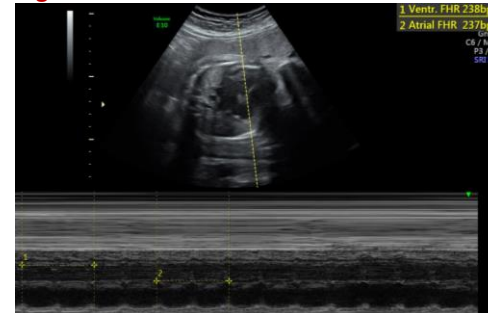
Ultrasound of FHR on M-mode
